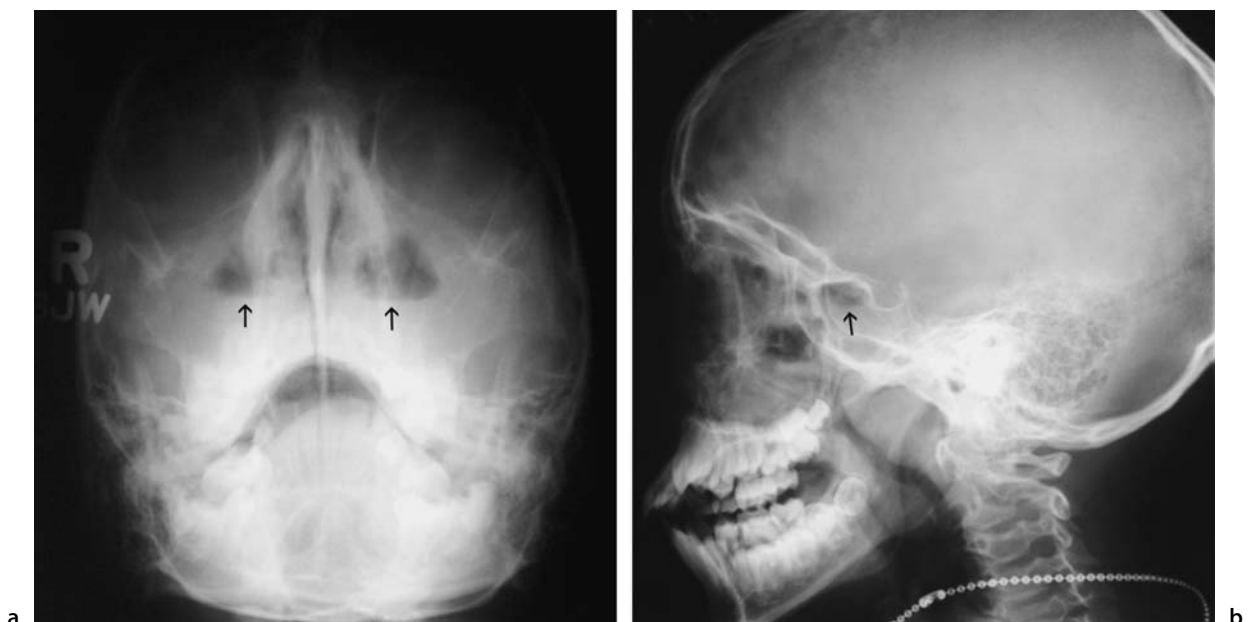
Acute sinusitis on plain films
